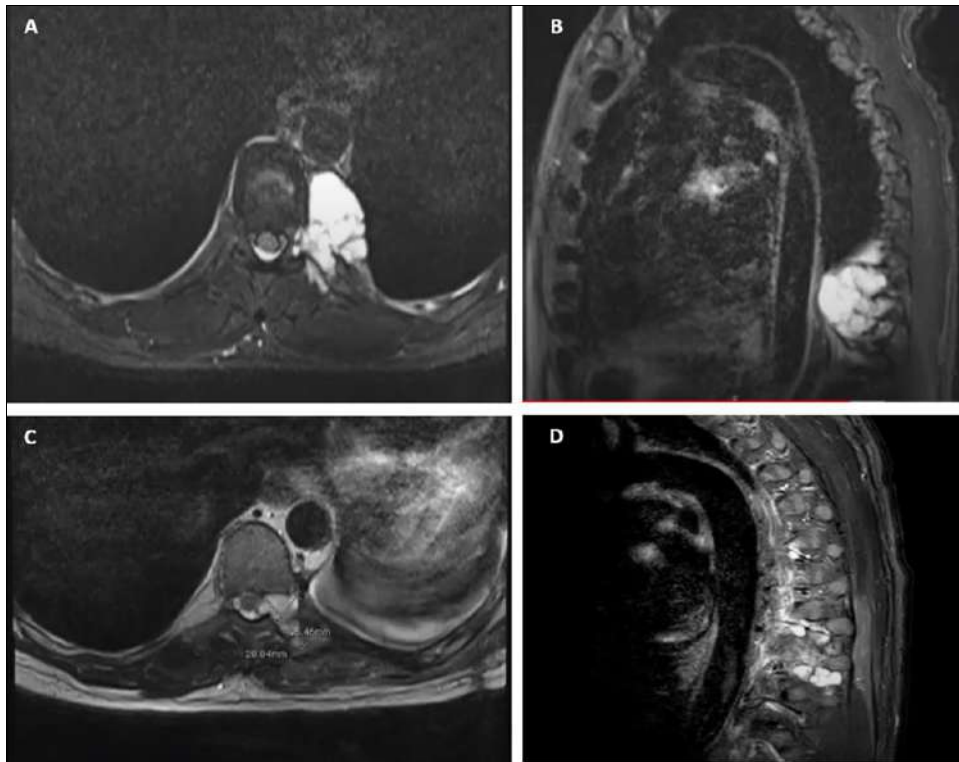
A, B, pre-operative MRI imaging, axial and sagittal respectively. C, D, post-operative MRI imaging, axial and sagittal respectively showing the residual tumor.
